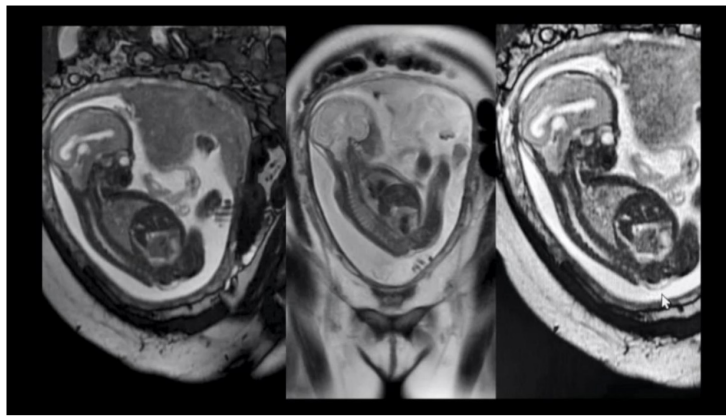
Pelvic MRI for the diagnosis of MMC
